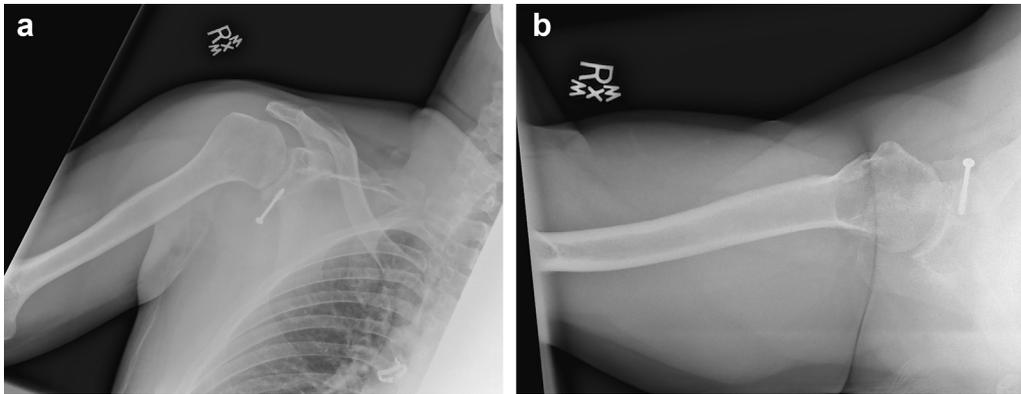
(a) True anteroposterior radiograph demonstrating a single partially threaded screw in glenoid with evidence of screw pullout. (b) Axillary radiograph demonstrating a single partially threaded screw in glenoid.
